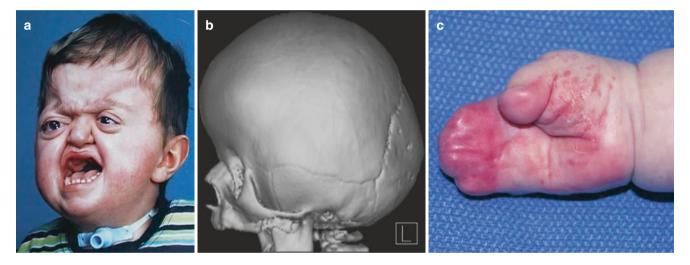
(a) Picture of face from front and side showing typical facies. (b) 3D CT head showing bicoronal synostosis. (c) Picture of hands/feet showing complex syndactyly
